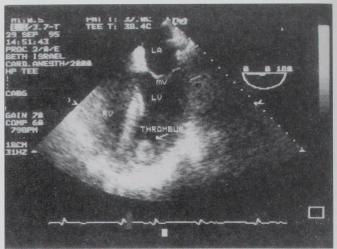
Transesophageal images of the left ventricular (LV) thrombus seen in case 1. (*A*) Thrombus in the LV apex (along the inferior wall, as imaged from the esophagus. (*B*) Thrombus in the apex, as imaged from the stomach. LA = left atrium; LV = left ventricle; inf = inferior wall.
